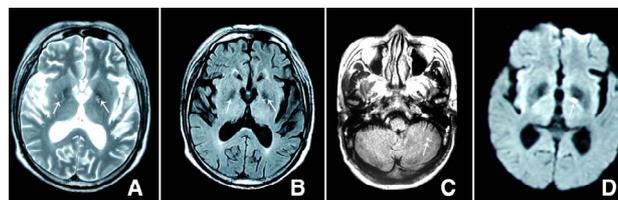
Brain magnetic resonance images, obtained on the 15 day. (A) T2-weighted image shows low signal intensities in the putamen and focal high signal intensity in the putamen (arrow); (B) The T1-weighted image shows low signal intensity in the putamen (arrow); (C) The Flair image shows high signal intensity in the left cerebellar (arrow); (D) The diffusion-weighted images shows signal intensity in the left putamen (arrow).
